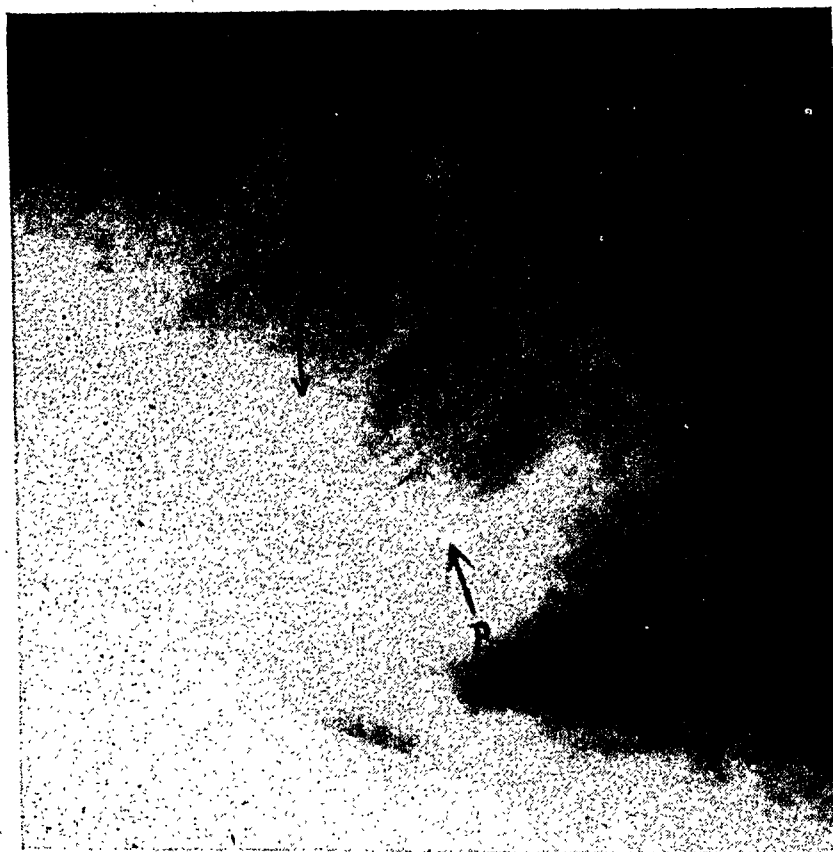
Radiographic view of the calcified mitral annulus fibrosus and of the posterolateral section of the aortic ring, bulging into the mitral orifice. *A.*, anterior branch; *P.*, posterior branch of the calcified mitral ring; and *A.r.*, calcifications in the protruding aortic ring. A 73-year-old woman with advanced hypertensive disease (blood pressure 230/105), diastolic and harsh systolic murmur. Sinus rhythm. Congestive failure, compensated.
